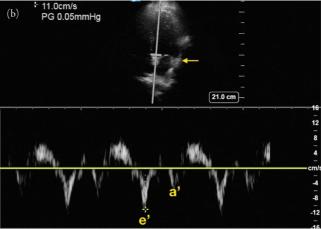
(a) Mitral inflow assessment using pulsed-wave Doppler. The gate is placed in the left ventricle use distal to the mitral leaflet tips. There are two waves, the early (E) wave associated with left ventricular expansion or active relaxation, and the atrial contraction (A) wave. Note that both waves are optimized using the scale and baseline functions. This tracing shows a normal E/A ratio of 1 to 2. (b) Tissue Doppler imaging assessment of mitral annular velocities. This shows a sampling of the left ventricular myocardial velocity at the septal annulus of the mitral valve, with a normal e' (>7 cm/s) measurement of 11 cm/s. The lateral annulus (arrow) can also be assessed, with normal e' >9 cm/s.
